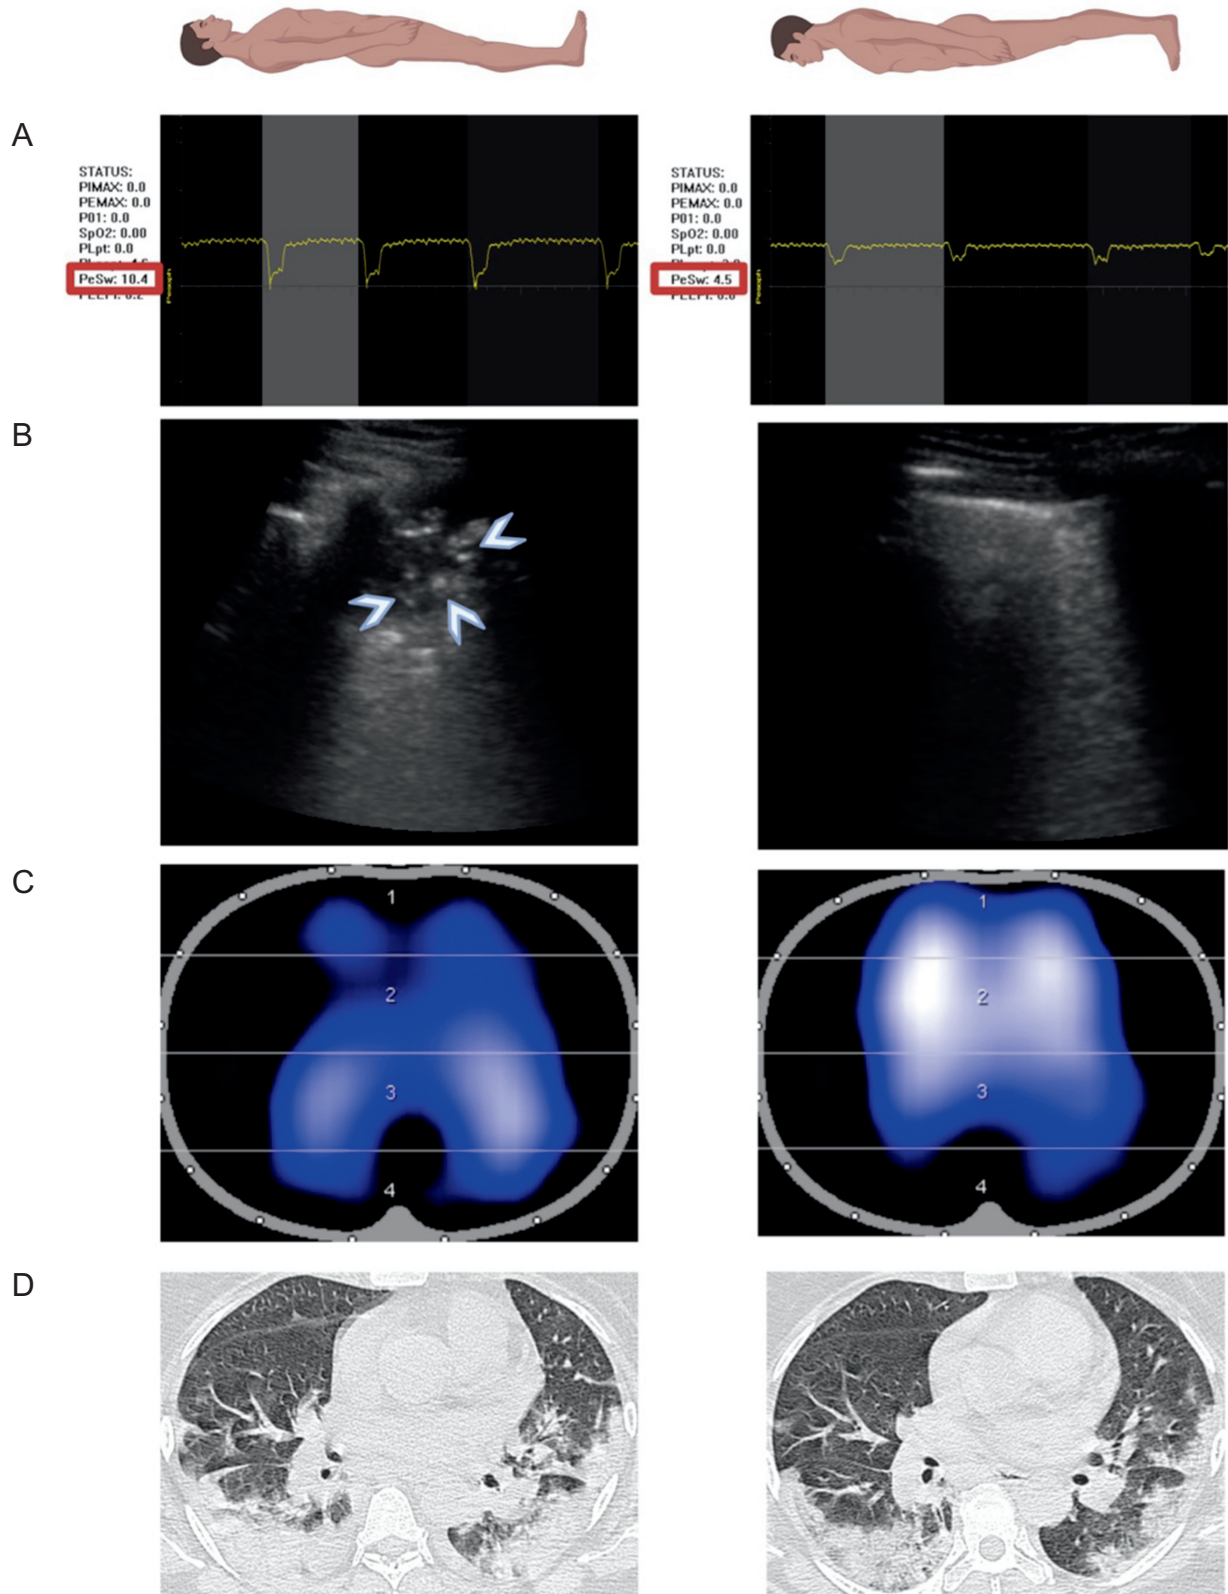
Physiologic responses to awake prone positioning (APP) as assessed by different bedside clinical tools. (A) Inspiratory effort measured by esophageal pressure swing, which decreased from 10.4 cm H₂O to 4.5 cm H₂O after 30 min of APP. (B) Lung consolidation tissue (arrow heads) disappearance after 1 d of APP as assessed by lung ultrasound. (C) Electrical impedance tomography showing homogenization of lung aeration after APP, especially at ventral lung regions (layers 1 and 2). (D) Computed tomography showing improving of aeration at both lung bases after 3 d of APP. Images are provided by Drs Li and Ibarra-Estrada from their unpublished studies. PeSw = esophageal pressure swing.
